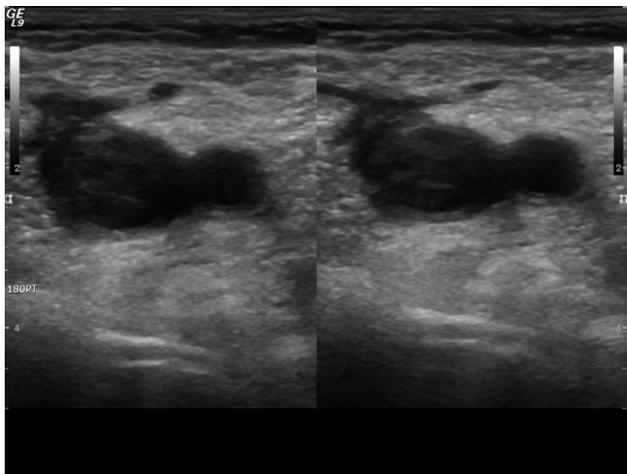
Lower extremity Doppler sonography with acute deep vein thrombosis in the left common iliac and femoral vein to crural veins.
